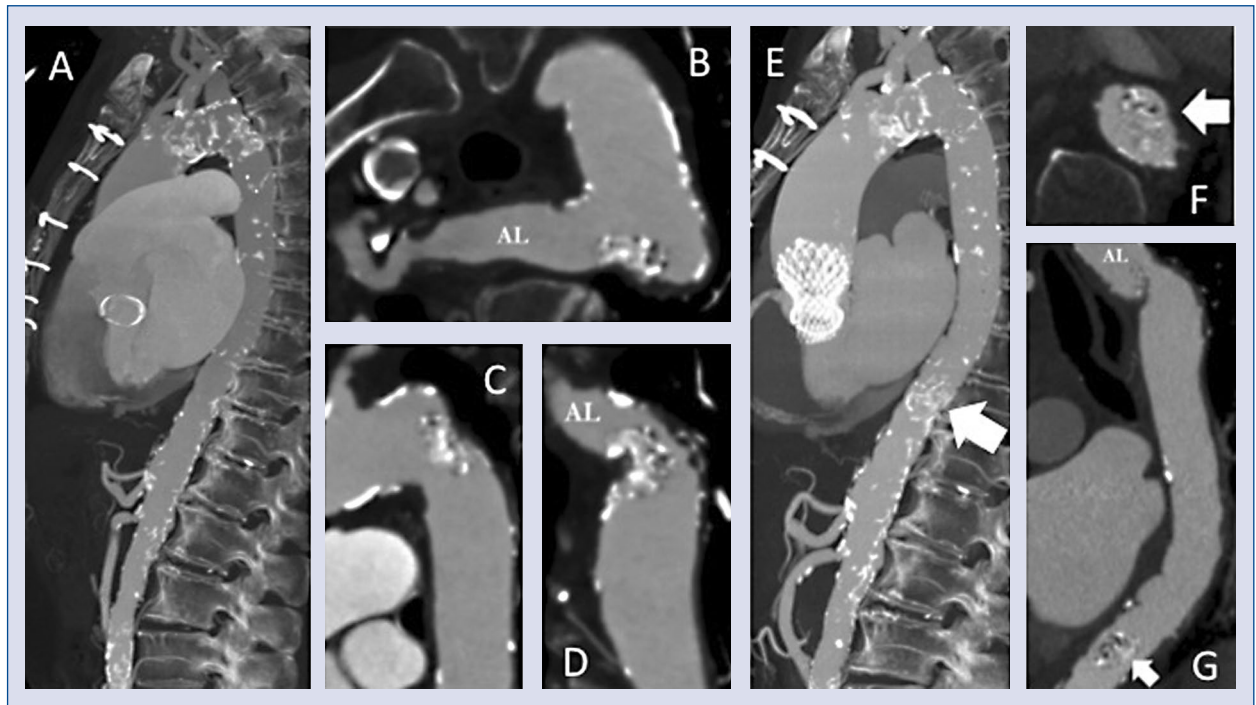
Maximum intensity projection (MIP) documents a severely calcified aortic arch (A). multi planar reformation (MPR) images show an arteria lusoria (AL) in axial (B) and large calcifications of aortic arch in sagittal (C) and coronal (D) views. After transcatheter aortic valve implantation (E), MIP shows the presence of previously undetected calcifications at the thoraco-abdominal district (arrow), with a bulk mass entrapped in the descending aorta (computed tomography axial scan, F), later confirmed at computed tomography angiography performed at 6-month follow-up (coronal view, G).
